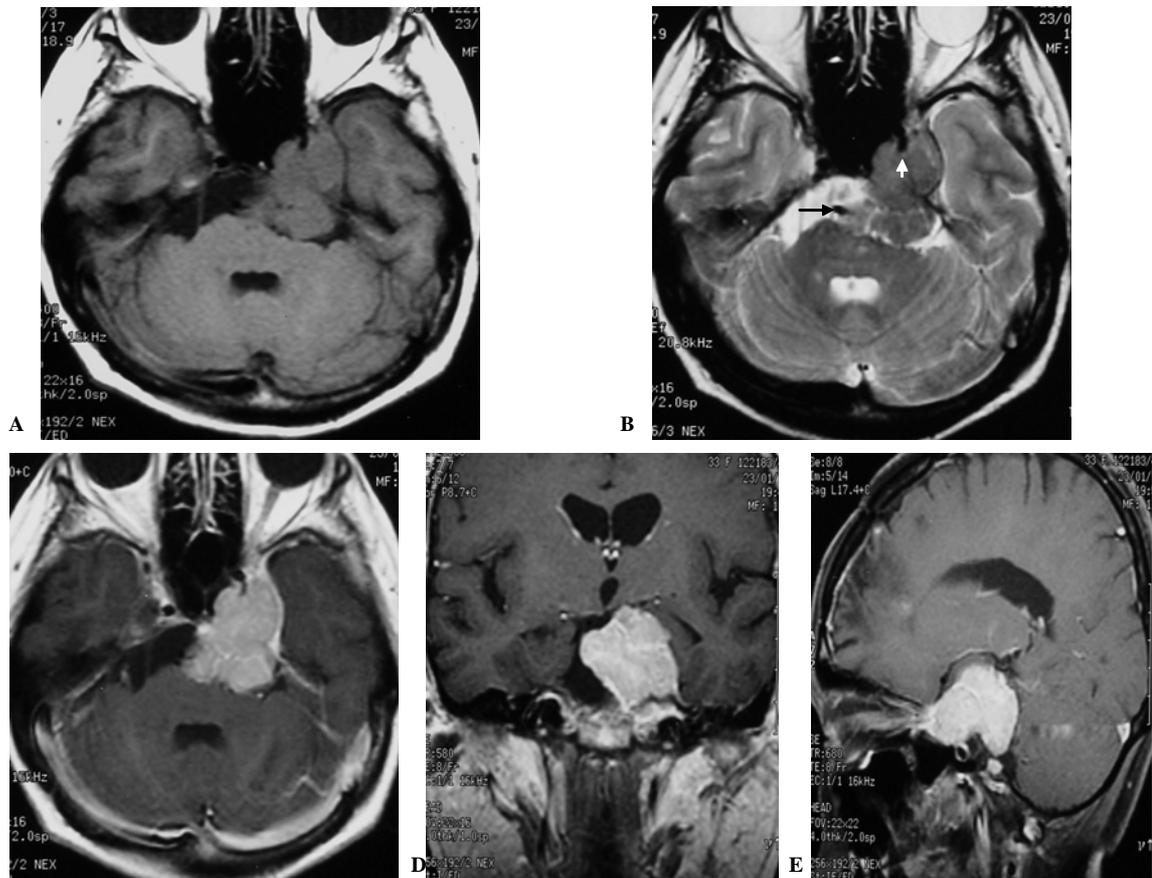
Case IV: A 30-year-old female presented with left ptosis and total ophthalmoplegia of the left eye. Axial T1-weighted (A) and T2-weighted (B) images show a 3x4 cm well-circumscribed extra-axial mass on the left side of the cavernous sinus and prepontine cistern, causing pressure effect on the pons and displaced basilar artery to the right side (black arrow). Encasement of the left internal carotid artery (white arrow) is noted. This lesion shows isosignal intensity to gray matter on T1-weighted image and minimally low intensity on T2-weighted image. Heterogeneous enhancement is observed after administration of contrast material (C,D and E)
